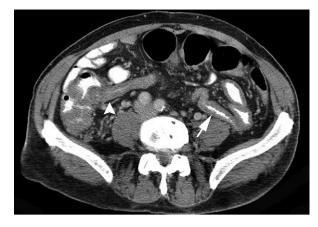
A 55-year-old man with *Campylobacter* enteritis. Axial CT image shows diffuse thickening of the small bowel (arrow) and the ileocaecal region (arrowhead). Nodularity is seen within the small bowel thickening (arrow). Note diffuse small bowel and caecal involvement with lack of mesenteric inflammation, fluid, or fibrofatty proliferation.
